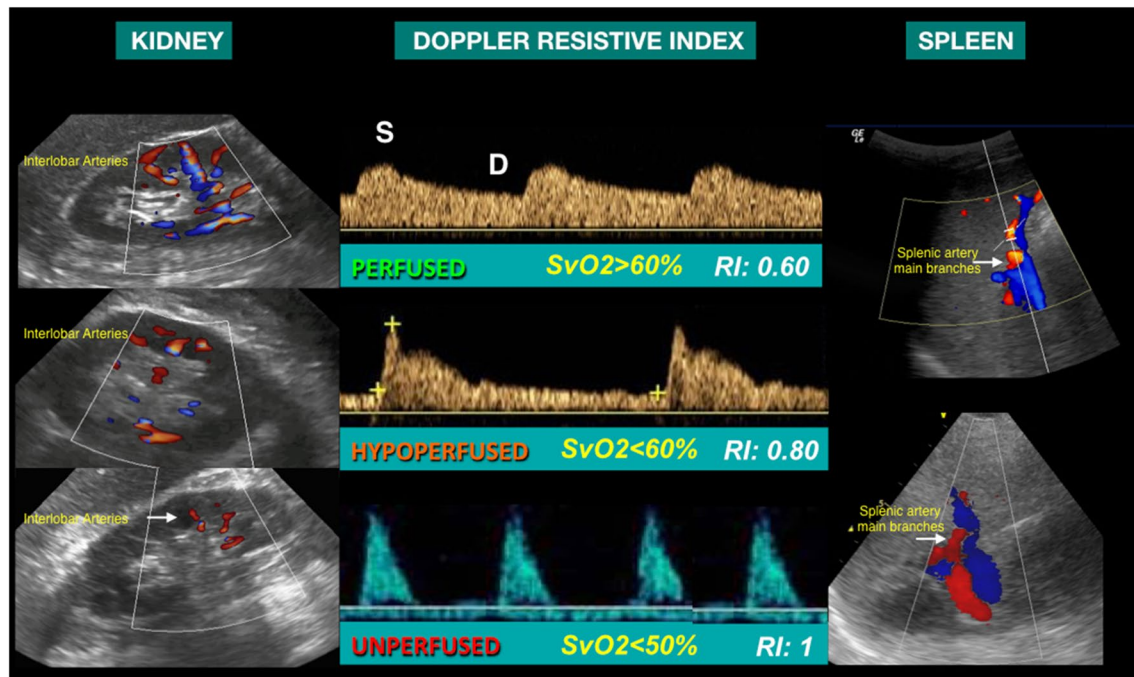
Different patterns of splanchnic perfusion inferred by Doppler resistive index: (1) perfused with a clearly visible diastolic phase (top), (2) hypo-perfused with lower diastolic phase (middle), (3) vascularized but unperfused where only the systolic phase of the cardiac cycle is visible without the diastolic (perfusional) phase (bottom). Color and Pulse Doppler Ultrasonography is usually performed with a low frequency probe (sector or convex array transducer) examination with the patient in supine position. Color Doppler is used to target the vessels while pulsed wave Doppler is used to sample the trace. Doppler ultrasound measurements are obtained in the interlobar arteries of the renal cortex or in the main branches of the splenic artery and the average retained for analysis to derive an index for the whole organ in order to minimize sampling error. Waveforms are recorded and Doppler resistive index calculated as the ratio $(S - D)/S$, where “S” and “D” stands for peak systolic and end-diastolic velocities, respectively (yellow crosses). Pulsed wave Doppler spectrum was increased by using the lowest frequency shift range that did not cause aliasing and the wall filter was set at a low frequency (100 MHz) [7, 13]
